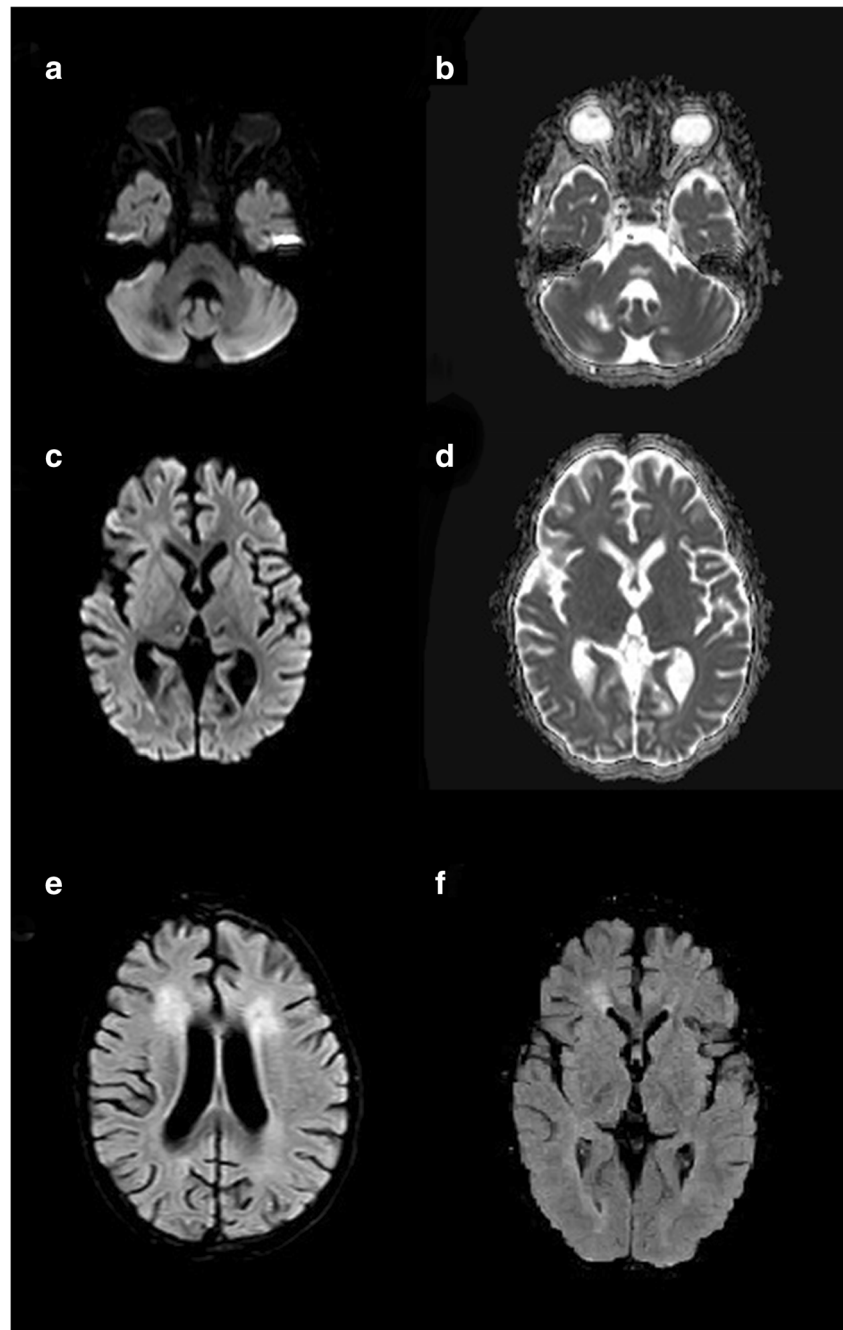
Diffusion restriction consistent with cytotoxic edema was present on the diffusion MRI examination performed 4 days after the patient's admission to the hospital. High signal intensities on DW images and low signal intensities on ADC maps were present in (a, b); bilateral cerebellar white matter, center and dorsal surface of the pons, and bilateral thalami
